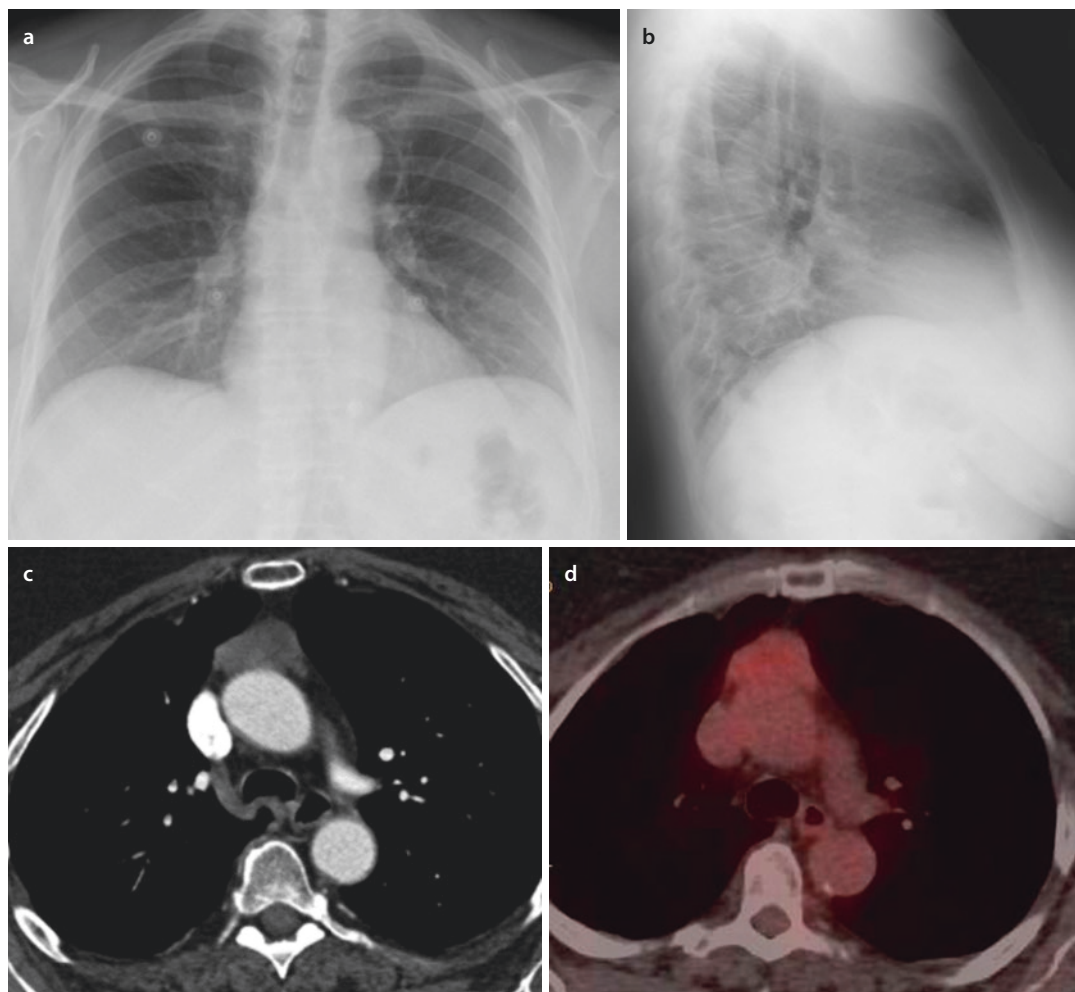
a PA and b LL view of a chest radiograph in a female patient suffering from myasthenia gravis. The PA view appears regular, whilst on the LL view, an enlargement of the anterior mediastinal compartment can be detected. c The patient underwent contrast-enhanced CT, showing a
